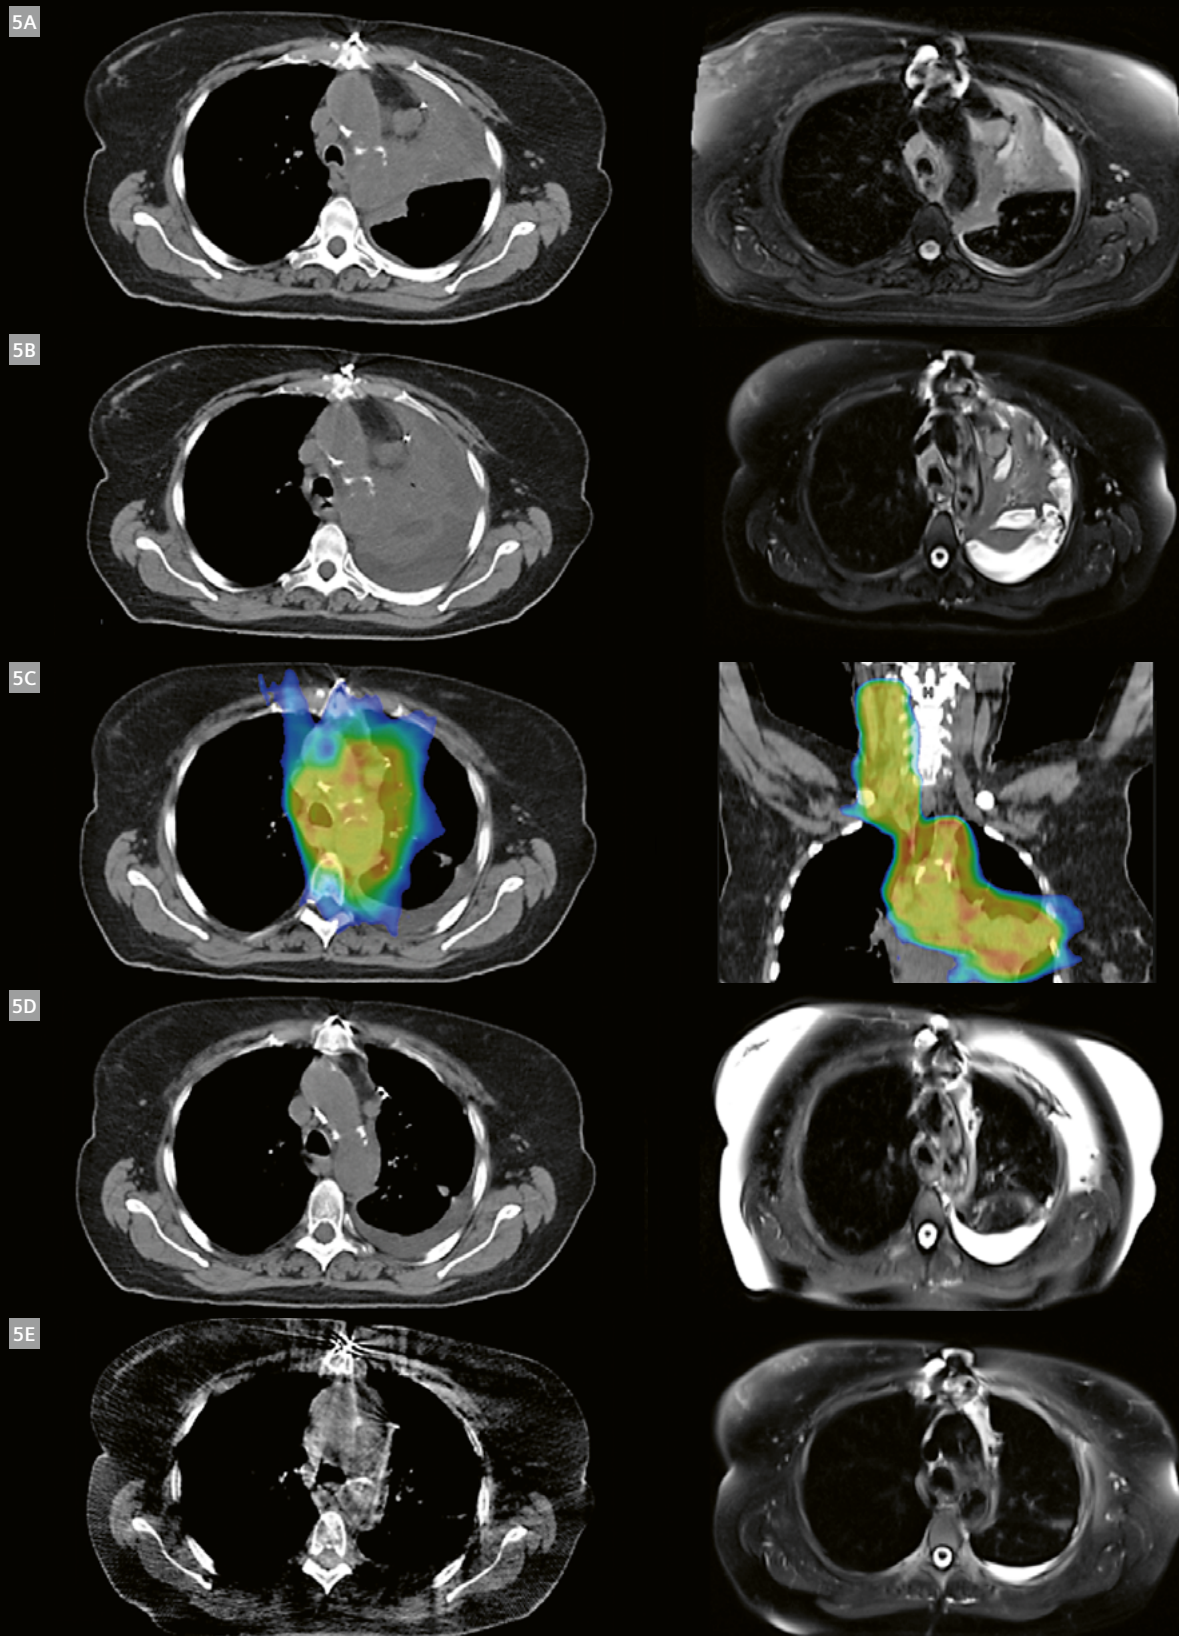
shows the planning CT scan with the corresponding MRI (T2-weighted Half Fourier Single-shot Turbo spin-Echo; HASTE), which was performed in shuttled position right after the planning CT. However, during the first week of treatment, the tumor had already progressed and the consecutive atelectasis increased in size, which then affected nearly the entire left lobe. Another planning CT scan was performed (Fig. 5B).
